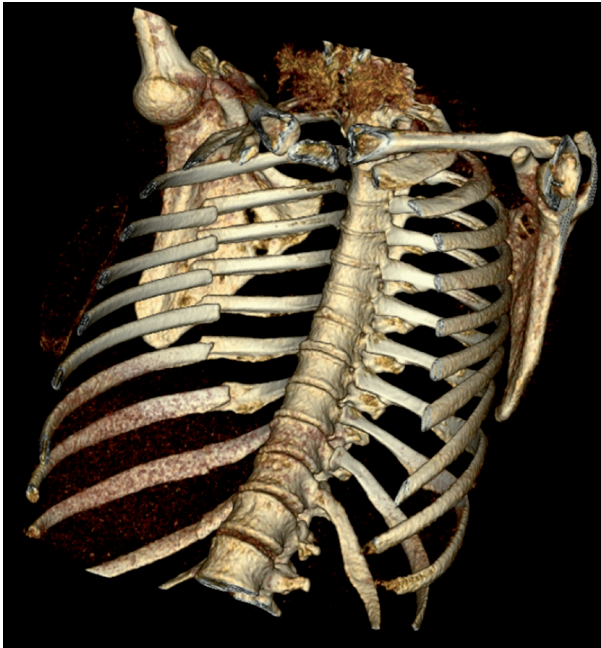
3D CT reconstruction of multiple rib fractures.
